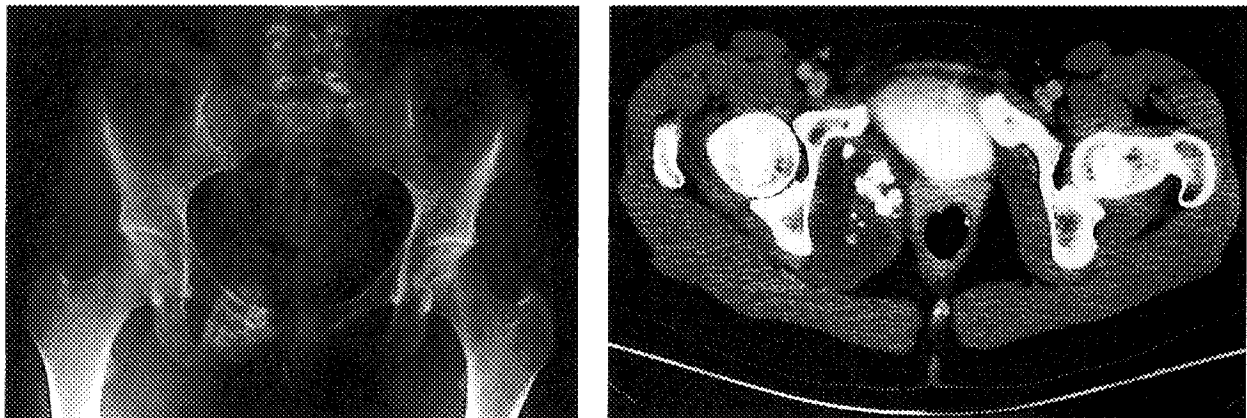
Left, AP radiograph of the pelvis of a 24-year-old woman with pain in the right side of the groin, showing a lesion that was thought to be a benign osteochondroma. Right, Subsequent CT scan shows a large soft-tissue mass in the pelvis that was consistent with chondrosarcoma.
